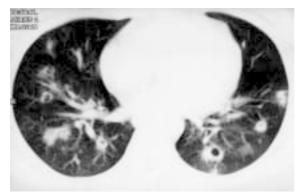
Follow-up CT of the thorax taken at the same level as Fig. 2 shows bilateral cavitating nodules.
